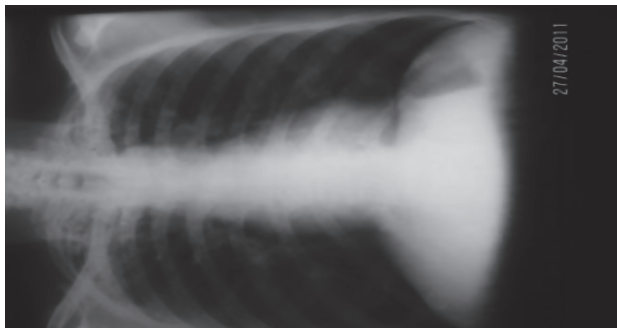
Chest radiograph showing streaky opacities with infiltration on the upper zones bilaterally suggestive of tuberculosis
